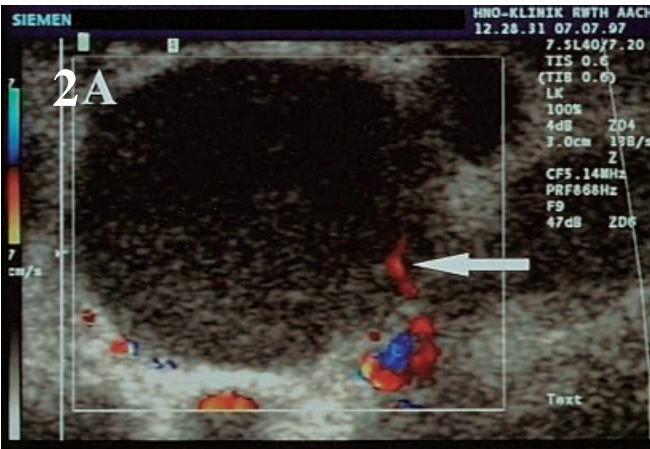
A, B Color-coded duplex sonography of a metastatic lymph node. While only a peripheral vessel (*large arrow*) is detectable before the injection of Levovist® as signal enhancer (A), small vessels (*small arrows*) can also be detected throughout the entire stroma after its injection (B), resulting in a heterogeneous pattern of vascularity
